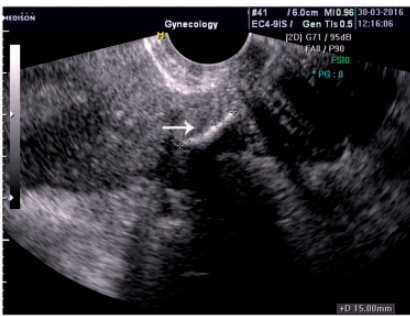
Pelvic ultrasound showing a hyperechogenic 15 mm long structure at the junction of the uterine corpus and cervix.
